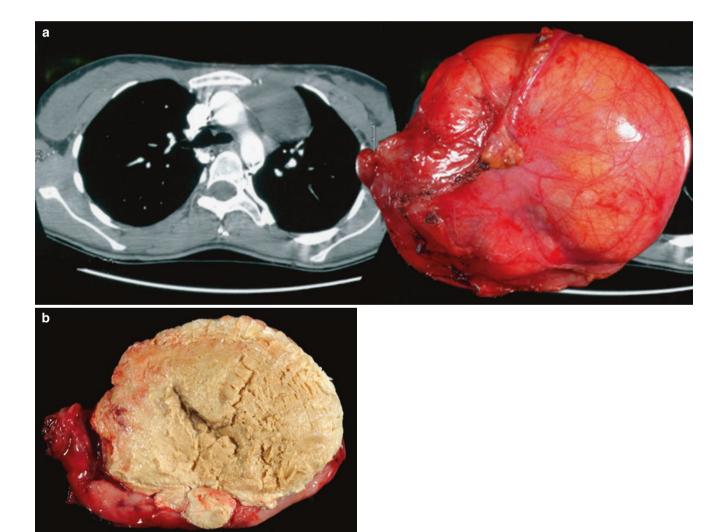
(a) Mediastinal mature teratoma compared to the CT image of the tumor. (b) Mediastinal teratoma showing sebaceous material
